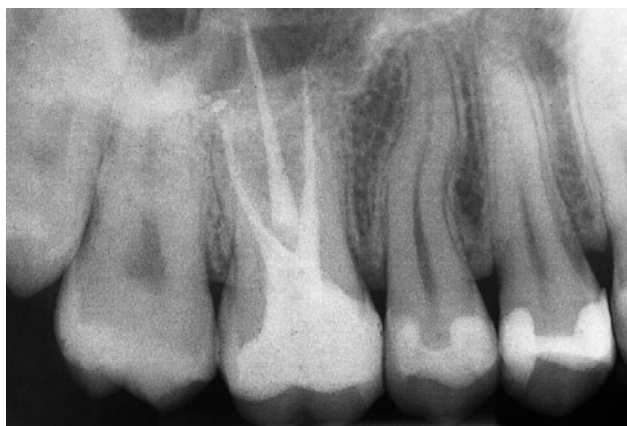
Radiographic image of tooth 26 at the one-year recall.
